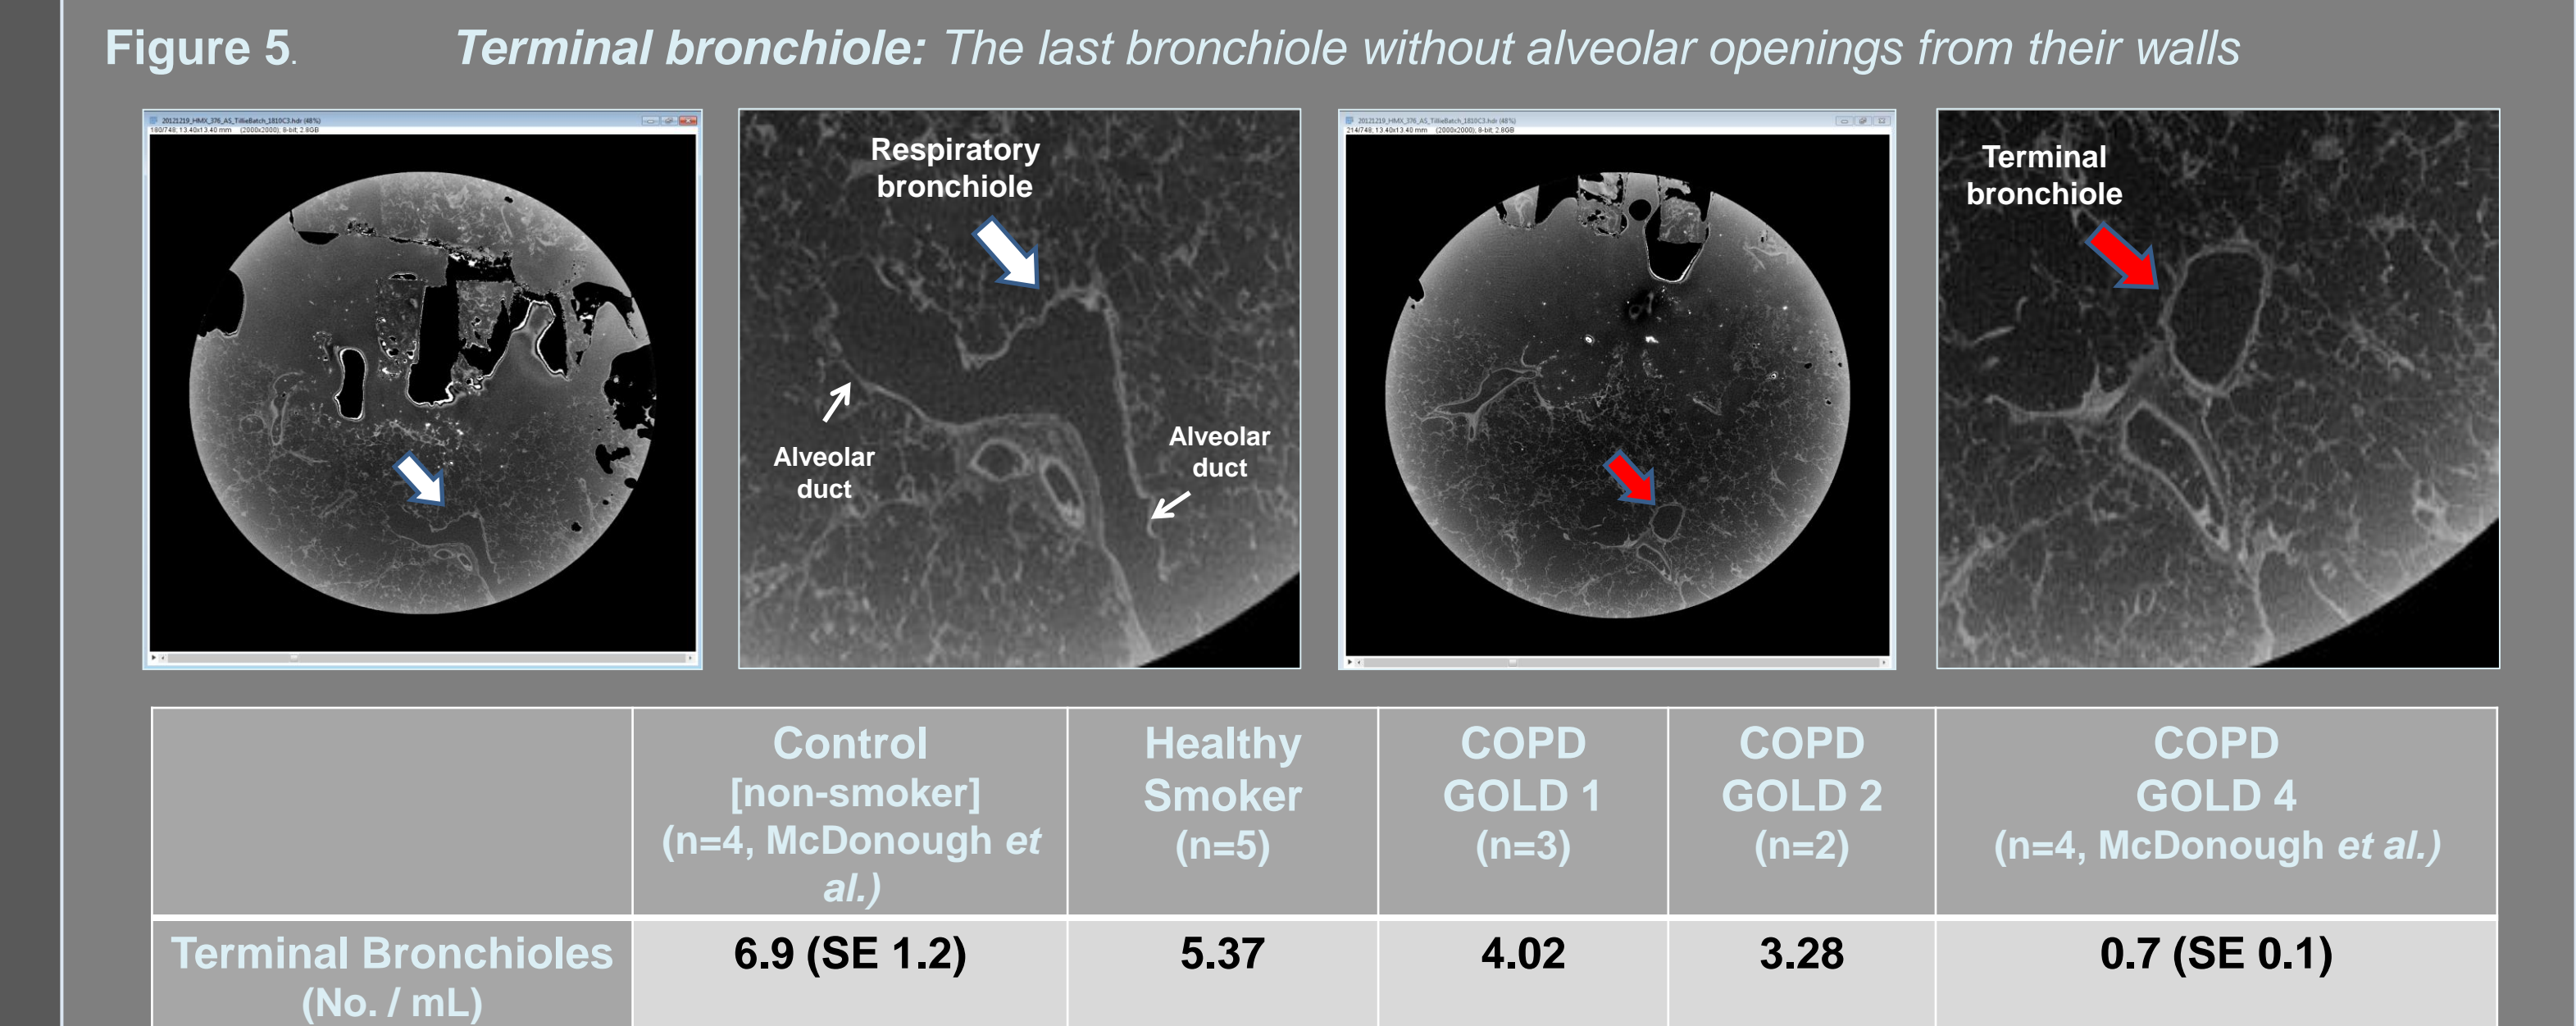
Measure of Terminal Bronchiolar number. Contiguous sections of each  $\mu$ CT scan are examined to identify terminal bronchioles.
